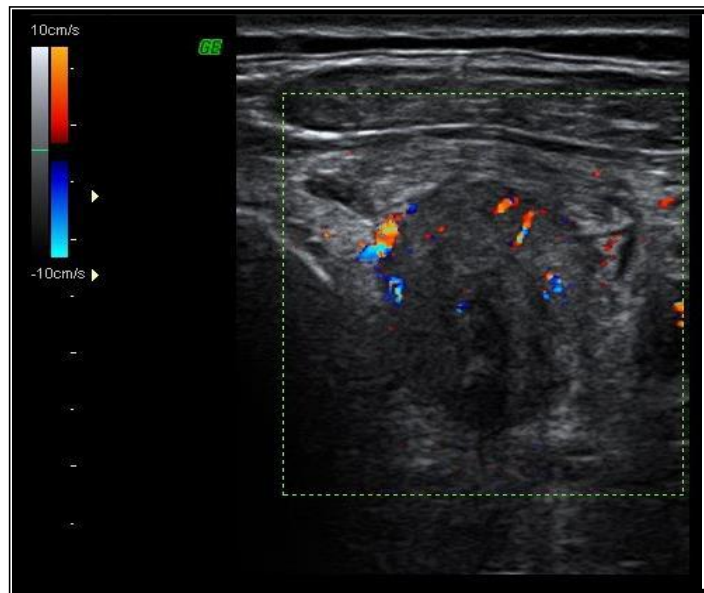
Ultrasound image of the right lobe of thyroid gland in a transverse plane shows:
